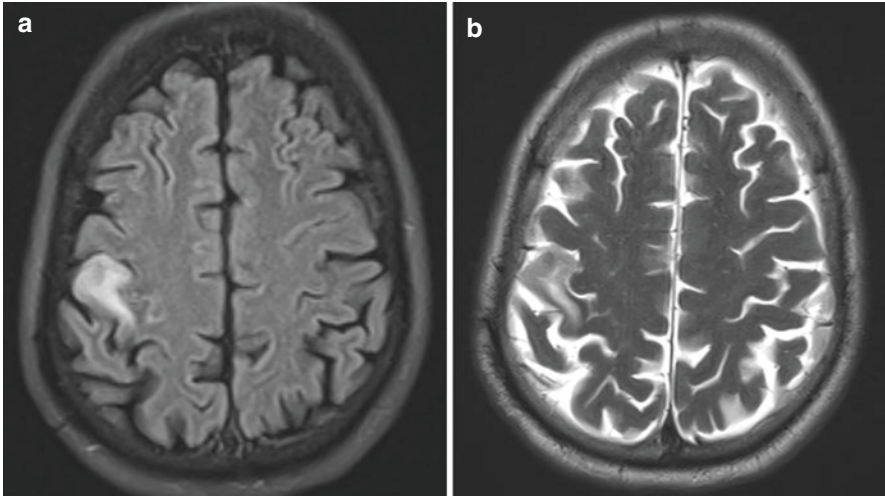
MR axial images showing patchy hyperintensity on the T2 (a) and FLAIR (b) images, respectively, suggesting early (acute infarct) stroke
